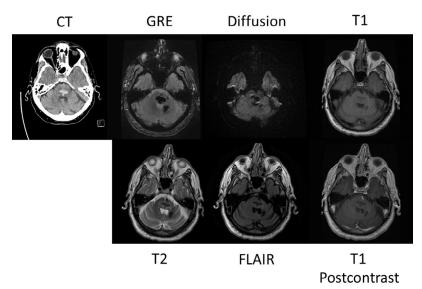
Acute pontine hemorrhage—CT shows hyperdense acute hemorrhage in the central pons. The hemorrhage is mildly hypointense on T1 and markedly hypointense on FLAIR and T2-weighted images, consistent with deoxyhemoglobin. Mild surrounding hyperintense edema is seen on FLAIR and T2-weighted images. There is no abnormal enhancement to suggest an underlying mass lesion. Deoxyhemoglobin causes local susceptibility effects, which results in low signal on DWI. There is also a more chronic hemorrhage with hemosiderin (T1 and T2 hypointense with susceptibility and no surrounding edema) in the medial left cerebellum.
